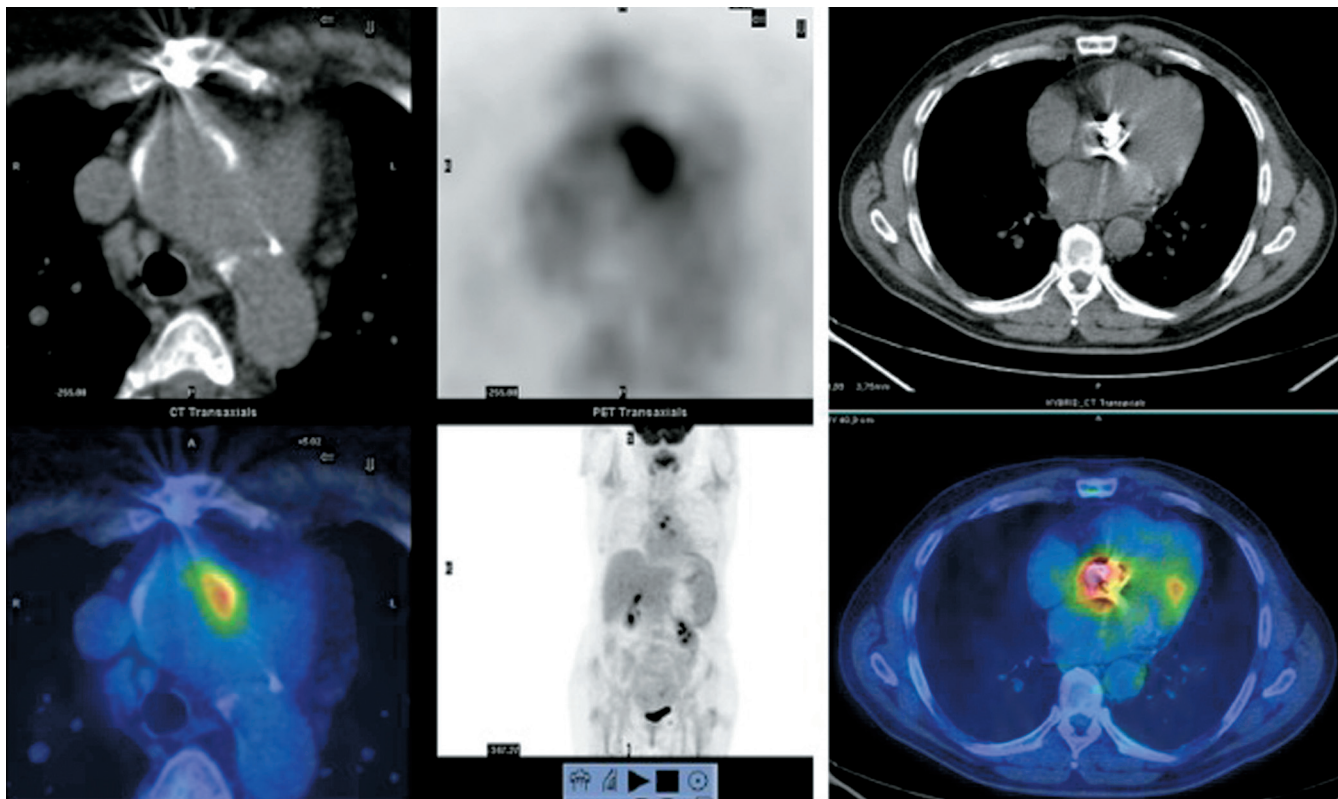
¹⁸F]FDG PET/CT in infection of the aortic arc and of the valvular prosthesis without involvement of the sternum.
